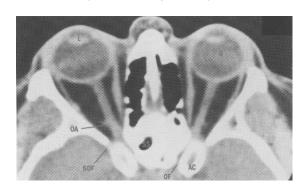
Normal axial CT scan of the orbit (Wirtschafter et al., 1992)
